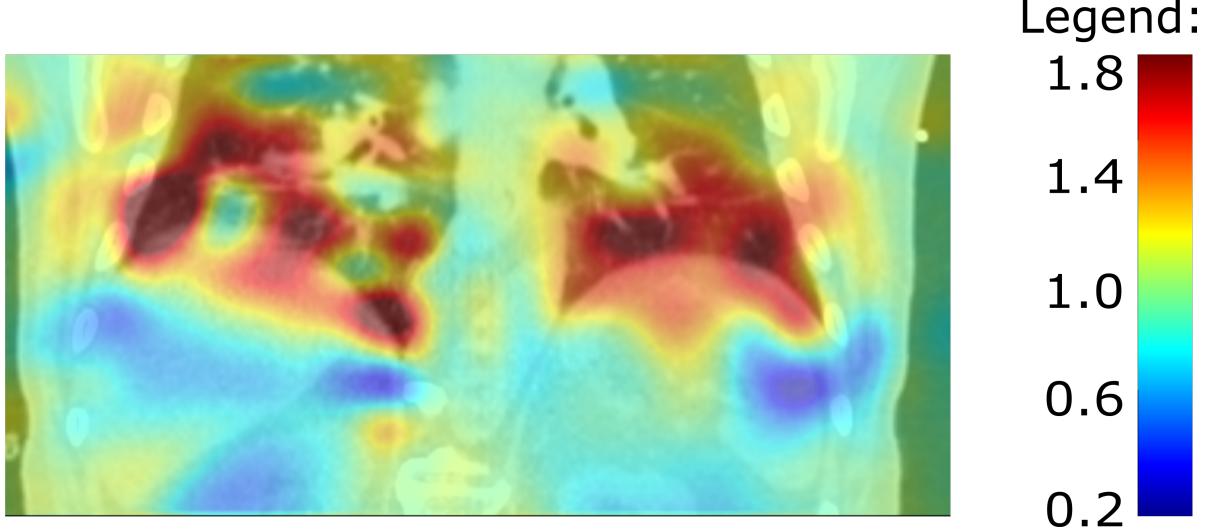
Image of Jacobian overlaid on CT scan. The average value of displayed Jacobian is 1.0 with 0.7 STD. CHECK!
